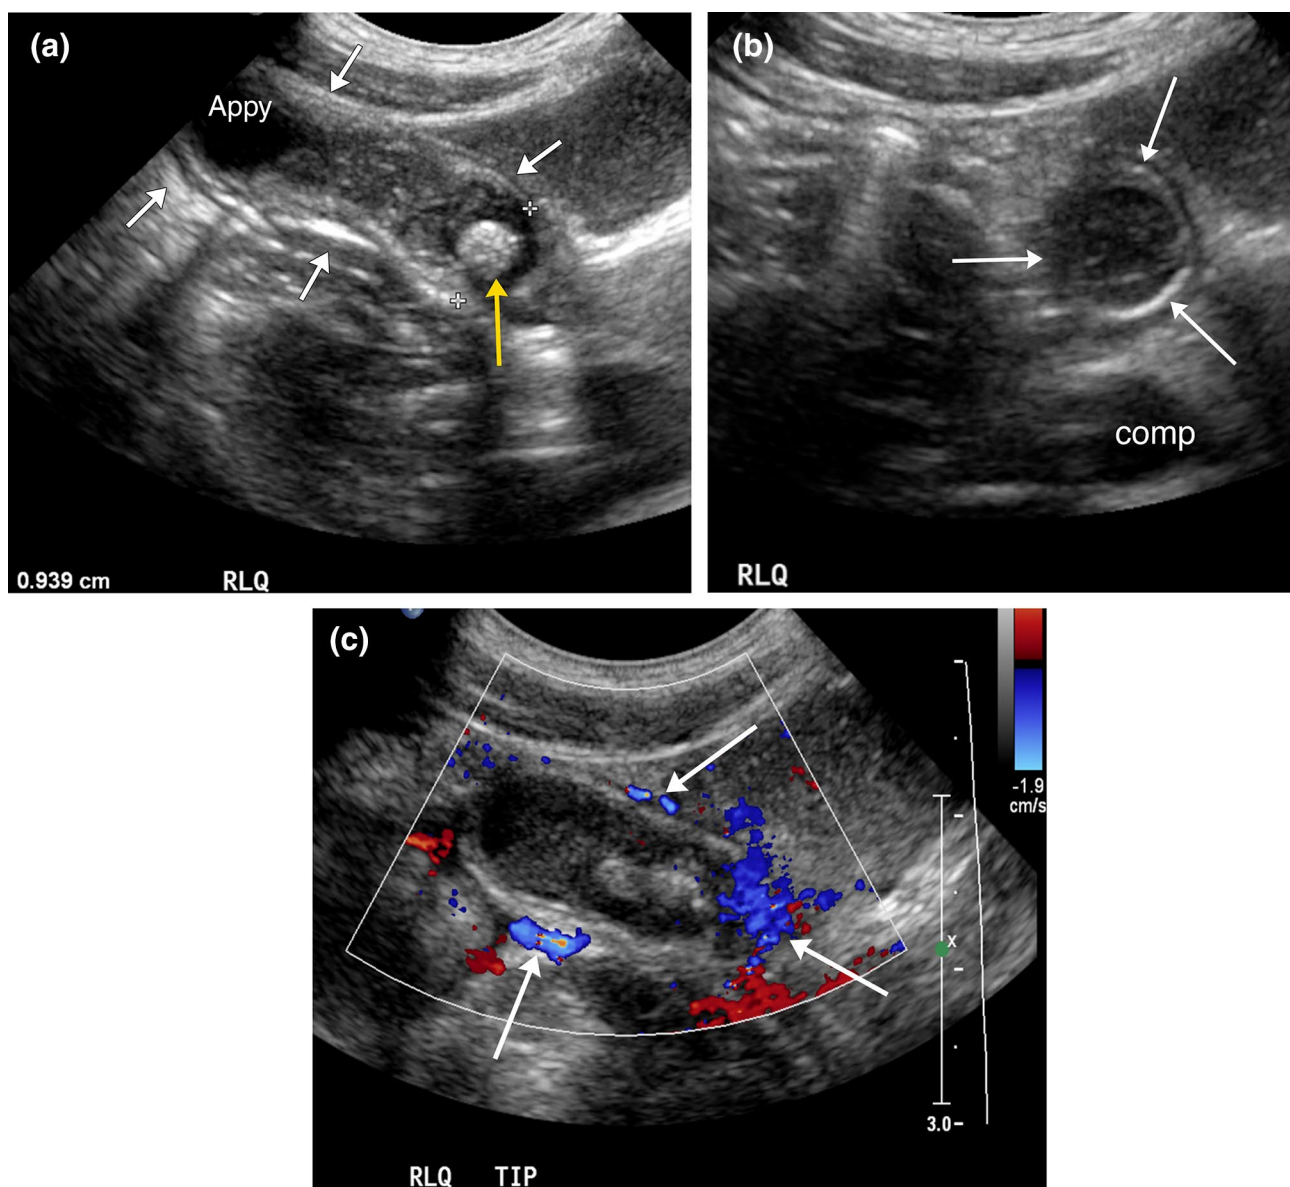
Non-complicated appendicitis in a 12-year-old male who presented to the emergency department with periumbilical abdominal pain lasting for 9 h. a Longitudinal and b transverse gray scale ultrasound images demonstrate dilated appendix (appy, arrows in a) (measuring 9.4 mm) filled with heterogeneous complex material
